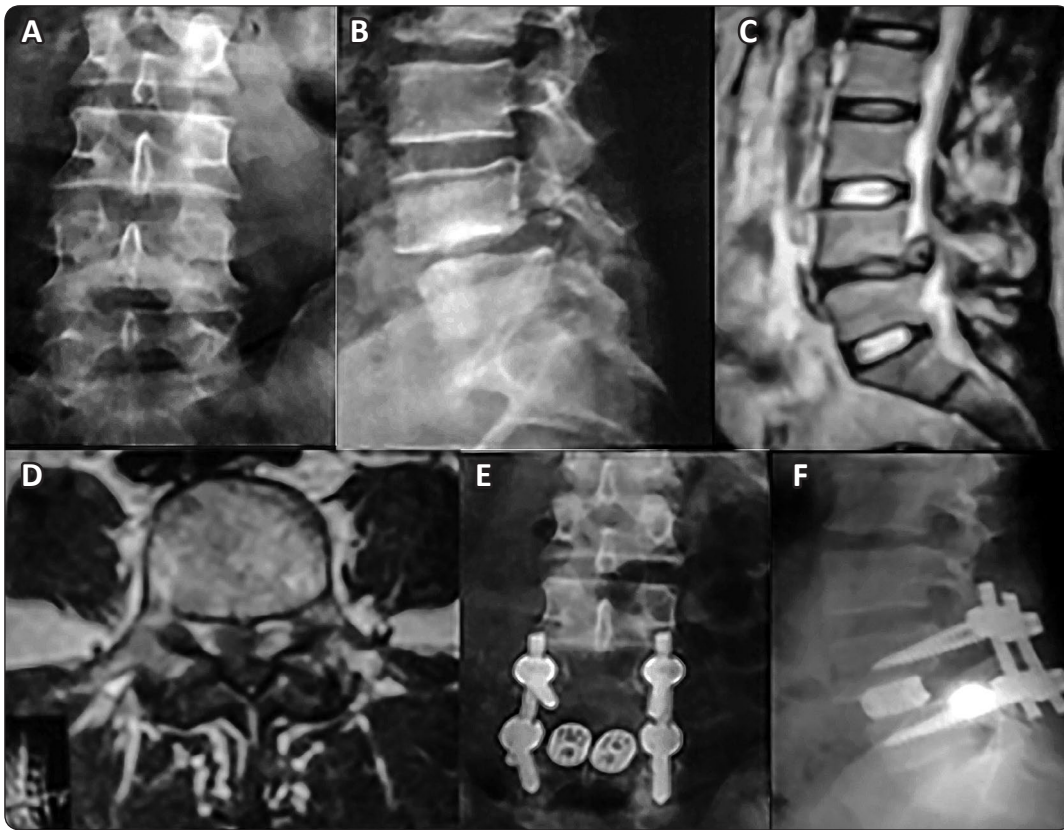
(A,B) standing AP and lateral plain radiographs showing spondylolisthesis L4-5 with huge degenerative disc prolapse shown at (C,D) T2 MRI sagittal (C) and axial (D) images treated by PLIF and transpedicular screws fixation as shown on AP and lateral postoperative plain radiographs (E,F).
